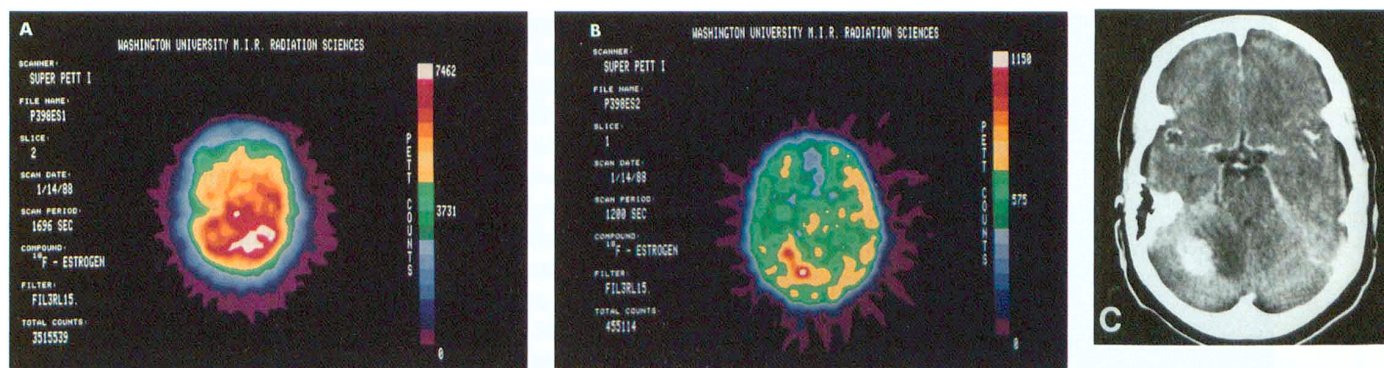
Time course of FES uptake in a cerebellar metastasis (Patient 2). (A) An early (0–20 min) PET image of the head demonstrates focally decreased activity in the left cerebellar hemisphere. (B) A later (90–110 min) PET image demonstrates increased accumulation of FES in the left cerebellar hemisphere lesion. Because the patient moved between the two image acquisitions, the early image is at a slightly lower level through the cerebellum than the later image. (C) A post-contrast CT image demonstrates an enhancing left cerebellar metastasis with adjacent edema. (All of the cross-sectional images are oriented as if viewed from above the patient.)
